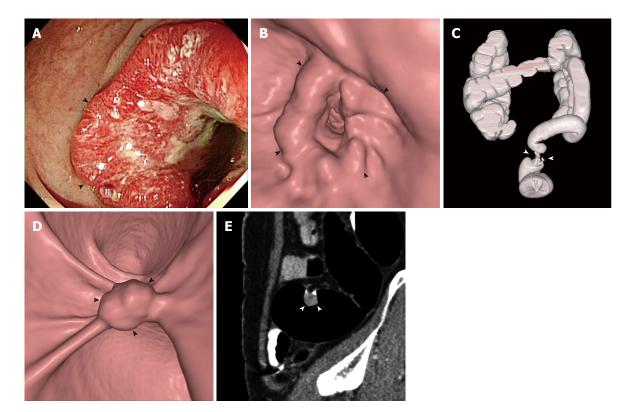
A 55-year-old woman with occlusive cancer in the upper rectum and a 17-mm synchronous cancer in the sigmoid colon. A-C: Colonoscopic (A), three-dimensional endoluminal computed tomographic (CT) colonographic (*i.e.*, virtual colonoscopic) (B), and three-dimensional volume-rendered (C) images of the colon show a luminal-encircling occlusive mass (arrowheads) in the upper rectum that impeded the passage of a colonoscope; D, E: Three-dimensional endoluminal (D) and two-dimensional sagittal (E) CT colonographic images show a 17-mm polyp (arrowheads) unassociated with invasive features in the sigmoid colon. The lesion was removed by surgery and pathologically confirmed as a cancer confined to the mucosa.
